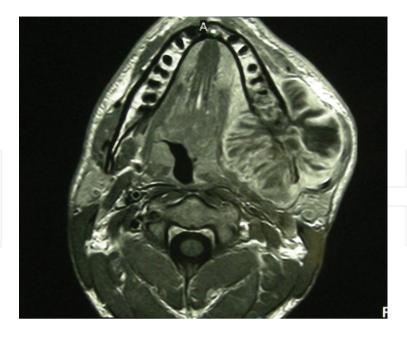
Preoperative MR imaging scan showing the extension of the mandibular neoplasm.
